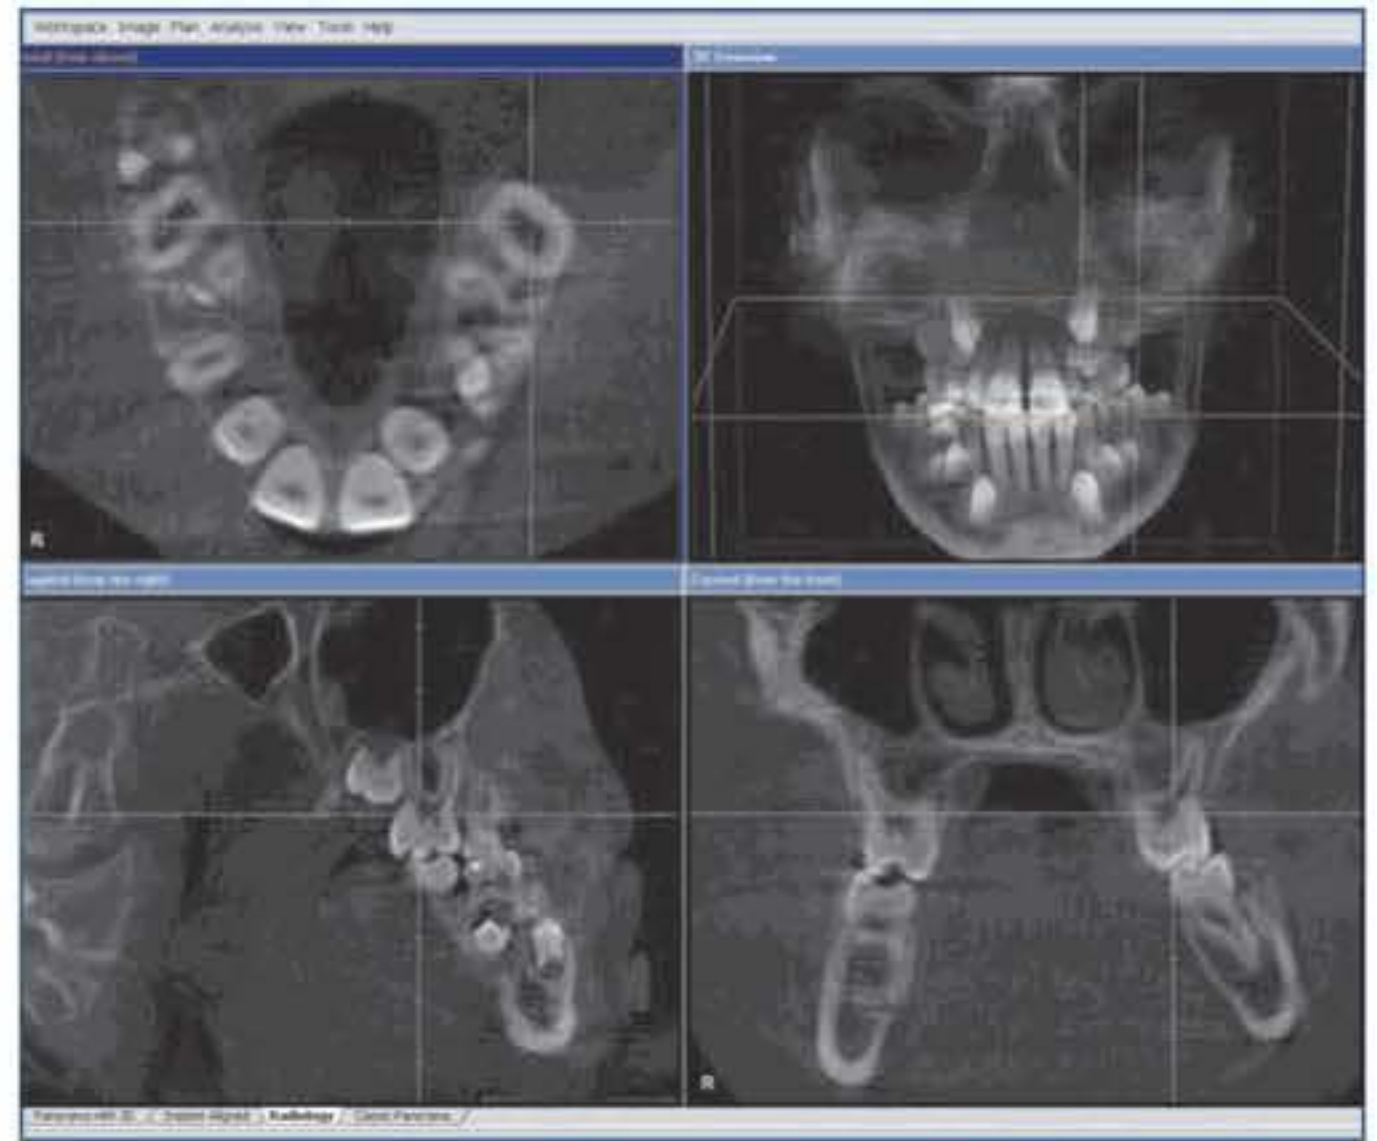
A 9-year-old boy with pronounced crowding in the maxilla and transverse discrepancy between the maxilla and mandible. The basal discrepancy is clearly visualized in the anterior and coronal view. In addition to assessing the origin of the width discrepancy, the 3D radiograph allows an estimate of the root growth of the teeth in the posterior region of the maxilla if they are to be used to anchor a maxillary expansion appliance.
